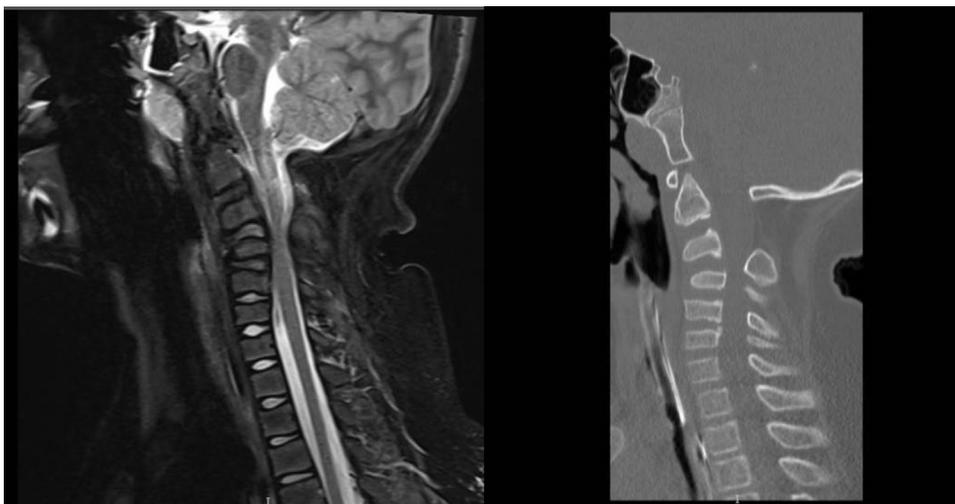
Preoperative sagittal magnetic resonance imaging and computed tomography images demonstrating spinal canal stenosis, bullet-shaped vertebral bodies, hypoplastic dens, malformed C2 and C3 posterior elements.
